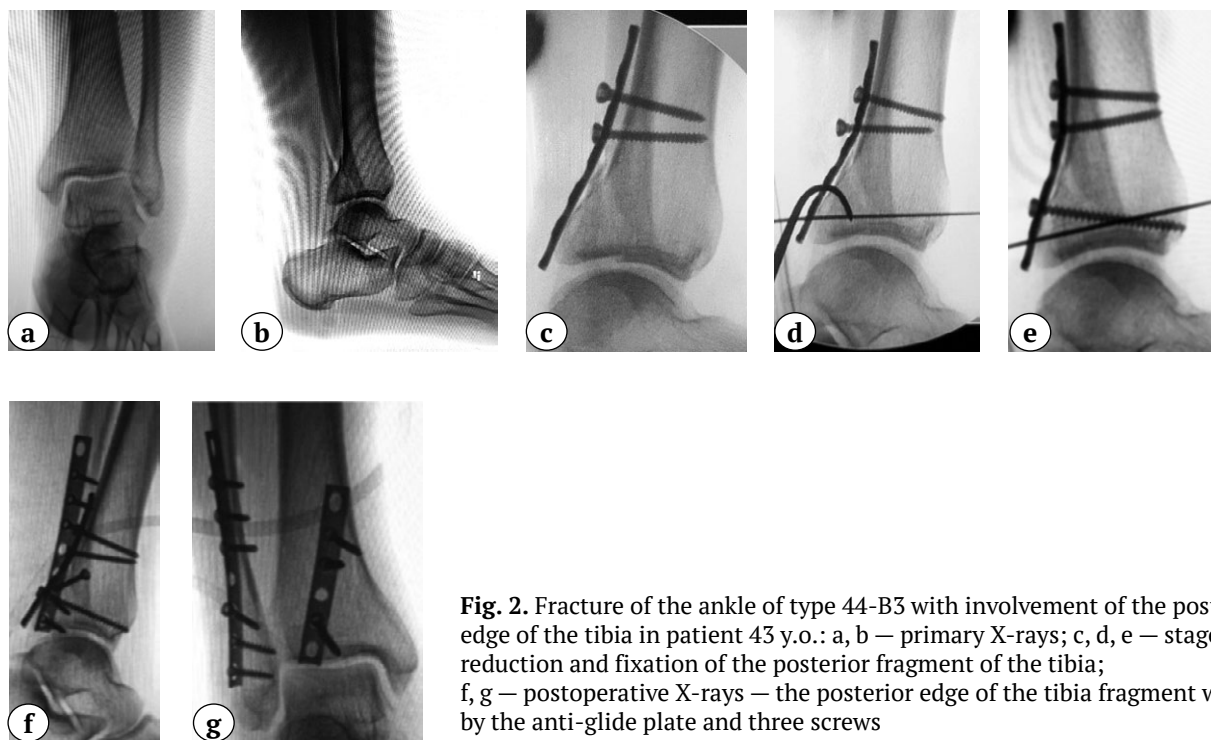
Fracture of the ankle of type 44-B3 with involvement of the posterior edge of the tibia in patient 43 y.o.: a, b – primary X-rays; c, d, e – stages of reduction and fixation of the posterior fragment of the tibia; f, g – postoperative X-rays – the posterior edge of the tibia fragment was fixed by the anti-glide plate and three screws
